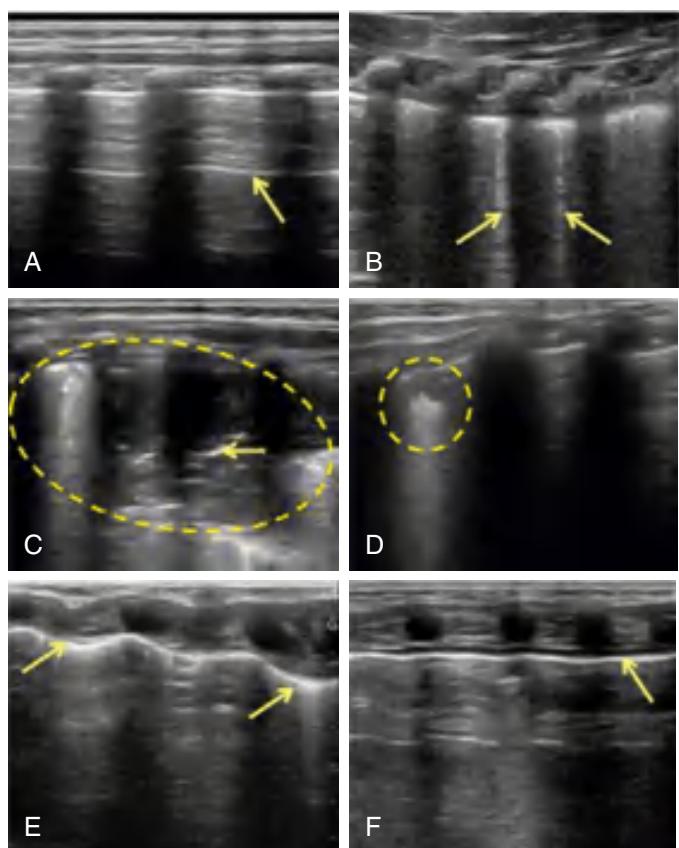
Lung ultrasound patterns. A, Negative lung ultrasound pattern with A-line (arrow) and no other findings. Positive lung ultrasound patterns with (B) B-lines (arrows); (C) large consolidation (>1 cm) with tissue-like echo-texture (circle) and ultrasonographic bronchograms (arrow); (D) small consolidation (<1 cm; circle); (E) pleural line abnormality with thickening and irregularity (arrows); and (F) pleural effusion (arrow). (From Varshney T, Mok E, Shapiro AJ, et al. Point-of-care lung ultrasound in young children with respiratory tract infections and wheeze. *Emerg Med J.* 2016;33:603–610, Fig. 1.)
